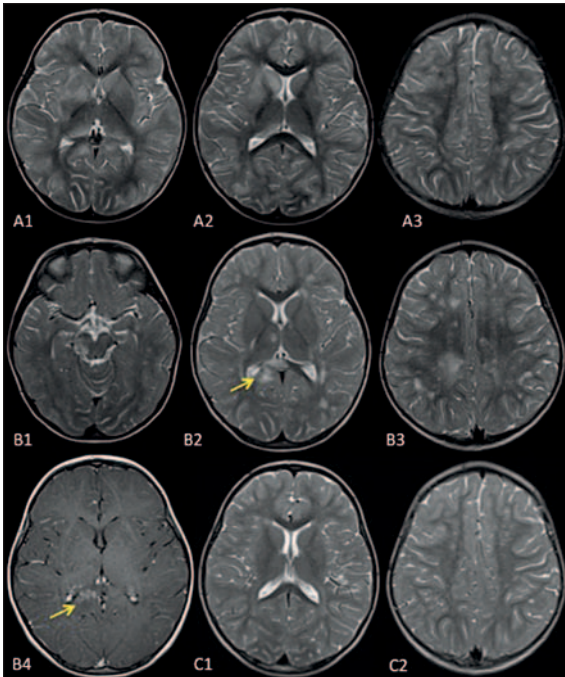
Brain MRI obtained during child's illness. A1-A3: first MRI, axial T2 weighted images, showing multiple parenchymal lesions, involving both white and grey matter regions, suggestive of ADEM. B1-B4: MRI obtained 6 months after ADEM diagnosis. Axial T2 weighted images (B1-B3) revealing several new lesions, involving both supra and infratentorial compartments. The arrow in B2 indicates the arch bridge lesion in the splenium of corpus callosum. Post contrast axial T1 weighted image (B4) showing that was an active lesion (arrow). C1-C2: MRI obtained 1 year after treatment with monthly IgIV. Axial T2 images show an important reduction in lesion load.
